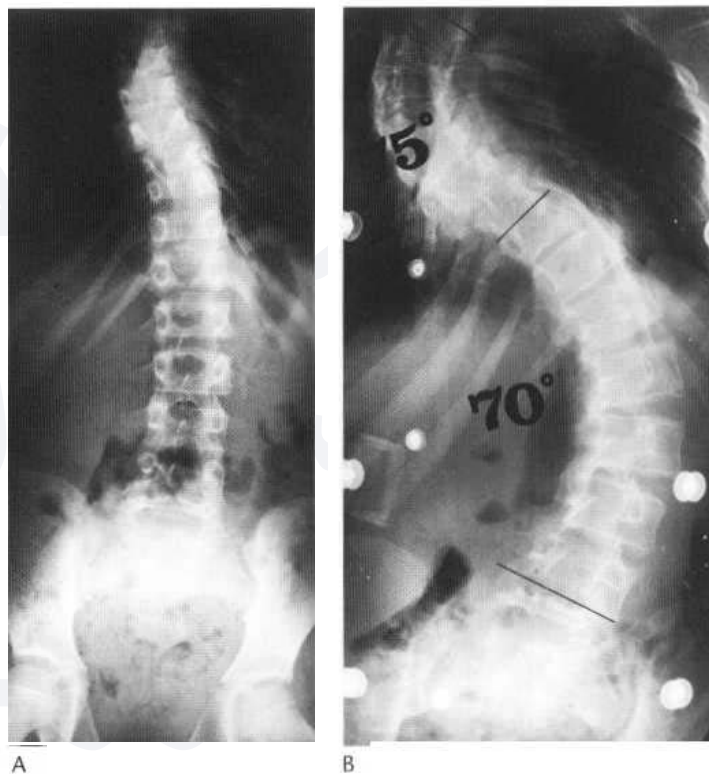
Adolescent idiopathic scoliosis. (A) The initial radiograph shows a moderate thoracic scoliosis with compensation inferiorly. (B) Four years later the curves have increased in the coronal plane, as well as the degree of spinal rotation. This is especially apparent in the lumbar region.
